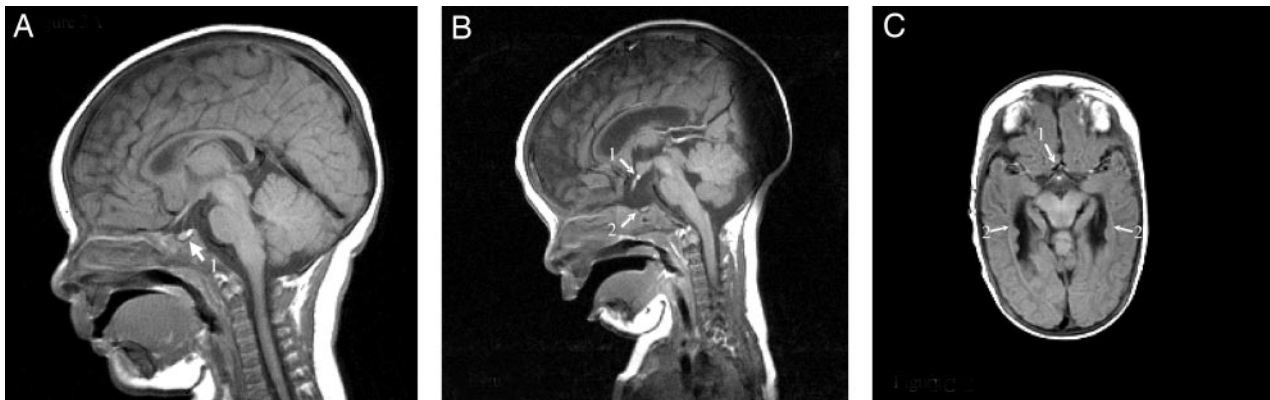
MRI of the brain. A, T1-weighted spin echo midsagittal image of a 3-month-old boy, screened for neonatal hemangiomas. Normal configuration of pituitary and pituitary stalk. Arrow points at sella turcica with pituitary anterior lobe (gray) and posterior lobe (bright white). B and C, T1-weighted spin echo images of patient no. 8 at age 3 months. B, Midsagittal image showing ectopic posterior pituitary lobe (arrow 1) at the median eminence in the floor of the third ventricle and small anterior pituitary lobe in undersized sella turcica (arrow 2). No manifest pituitary stalk. C, Transversal image showing posterior pituitary ectopia (arrow 1) and bilateral periventricular nodular heterotopia (arrows 2).
